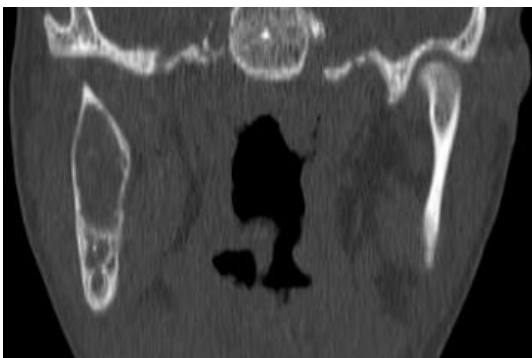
CBCT coronal view shows morphological alteration on right side of the tmj in comparison to left side
